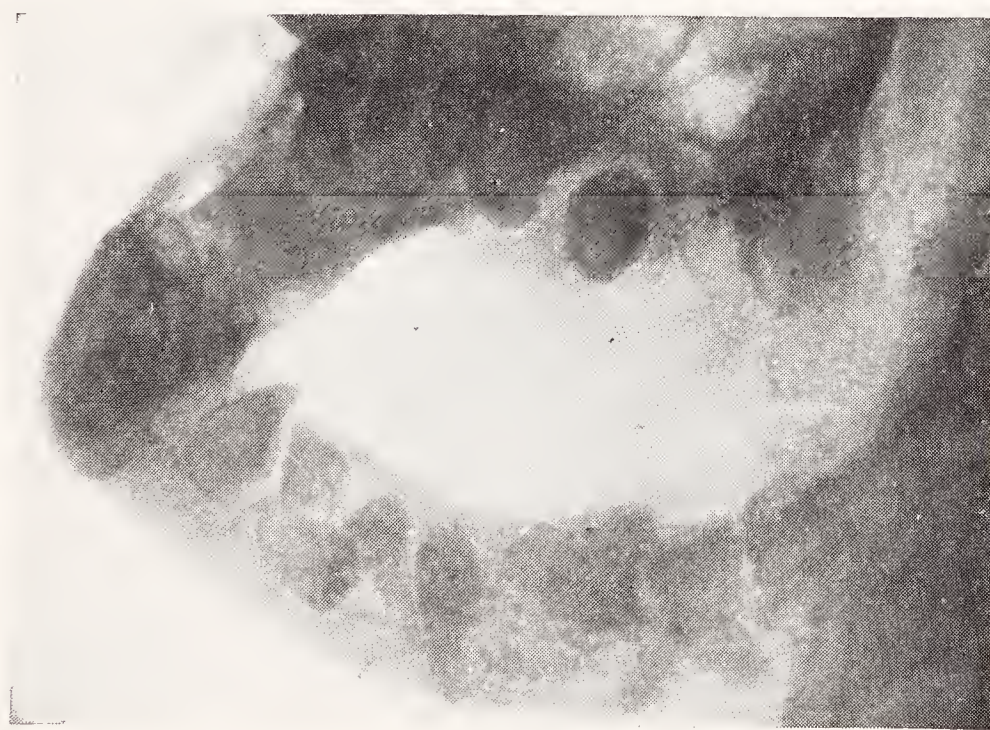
Radiograph showing multiple unerupted teeth in the edentulous mandible of a woman, aged twenty-eight years. (Ivy, Dent. Cosmos.)
